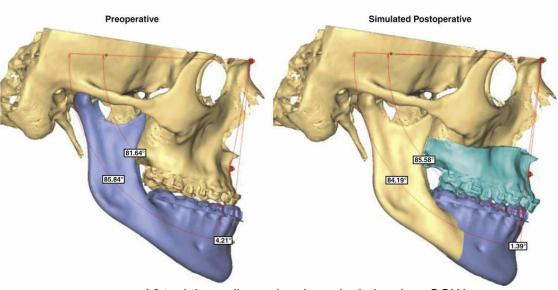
Virtual three-dimensional surgical planning. *CCW*, counterclockwise; *CT*, computed tomography; *CW*, clockwise; *SNA*, sella-nasion–A point angle; *SNB*, sella-nasion–B point angle.
